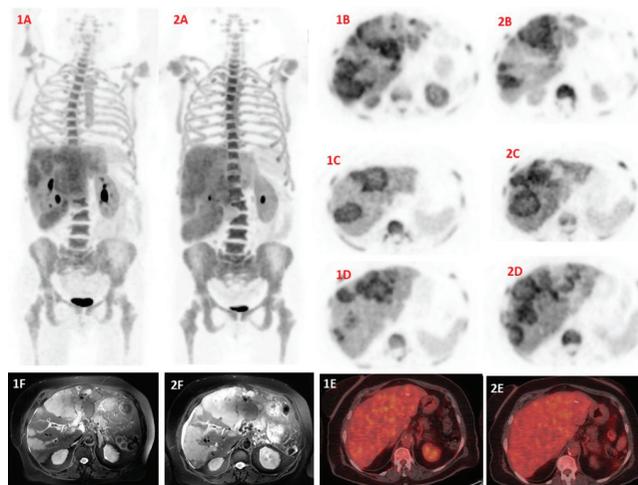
¹⁸F-FLT PET MIP images before (1A) and after (2A) TARE therapy of a 70 years old female patient with HCC. Axial ¹⁸F-FLT PET images revealed hypermetabolic liver lesions (SUV_{max}: 16.1) before embolization (1B, 1C, 1D); post-therapy images revealed decreased activity on the left liver lobe, but most of the lesions were still hypermetabolic (SUV_{max}: 16.4) (2B, 2C, 2D). Pretreatment MR revealed multiple contrast-enhanced tumoral foci; after treatment, there were new lesions and progression on all lesions. T2-weighted MR shows multiple foci on both lobes before (1F) and after (2F) therapy. Tumoral foci were ¹⁸F-FDG non-avid (1E) and non-avidity did not change after TARE (2E)
